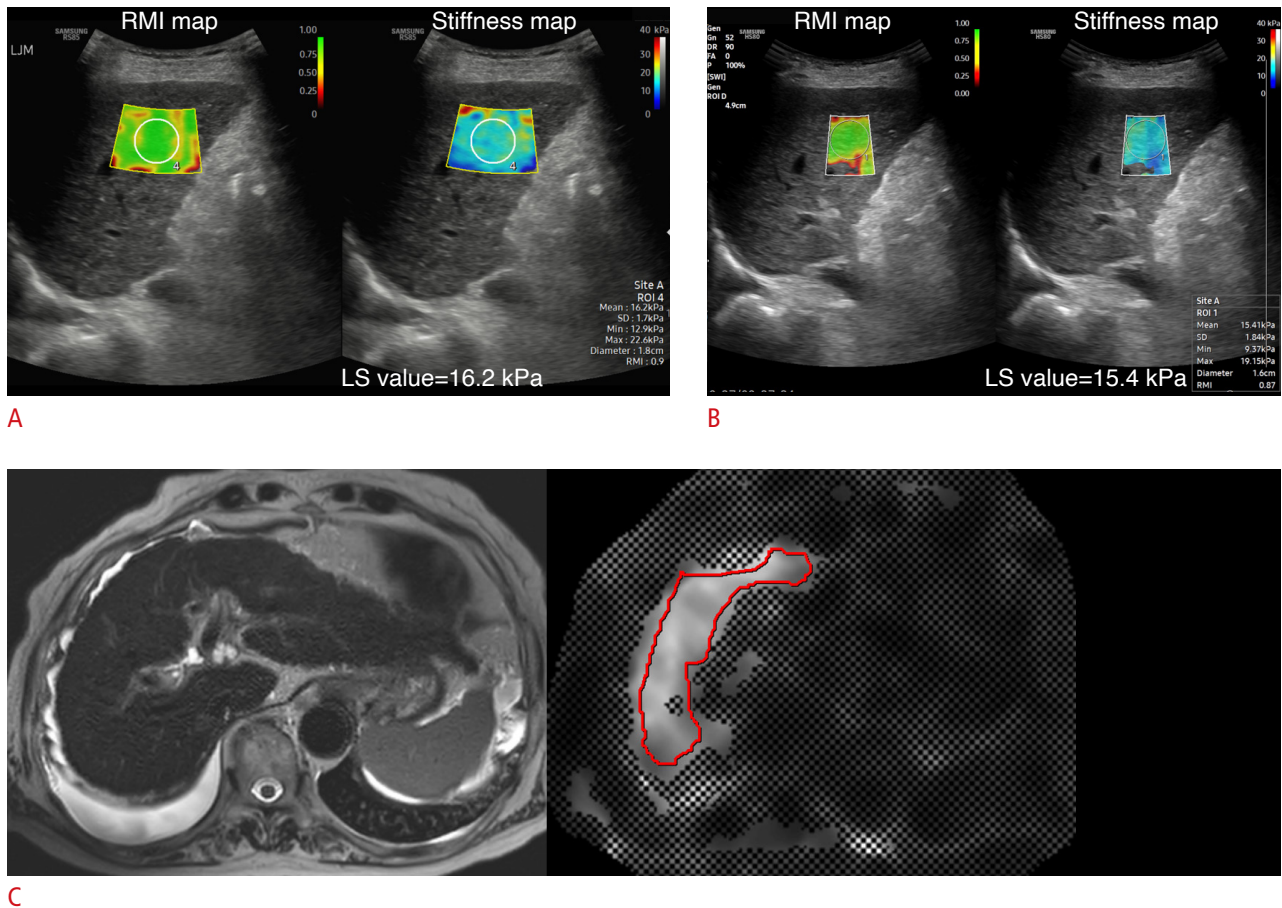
An example of a liver stiffness (LS) measurement in an 83-year-old woman with hepatitis C–related cirrhosis. Two-dimensional shear wave elastography with the plane wave imaging (PWI) technique (A) and the multi-beam (MB) technique (B) generated both a reliability measurement index (RMI) map (left) and stiffness map (right) simultaneously. When a circular region of interest was selected guided by the RMI map, the liver stiffness value was automatically displayed. C. On magnetic resonance (MR) elastography, referring to the T2-weighted image (left), a free-hand region of interest was drawn on the unmasked area of the confidence map (right), excluding large vessels and liver edges. In this patient, the measured liver stiffness values were 16.2 kPa (PWI), 15.4 kPa (MB), and 4.2 kPa (MR elastography, F3), respectively.
